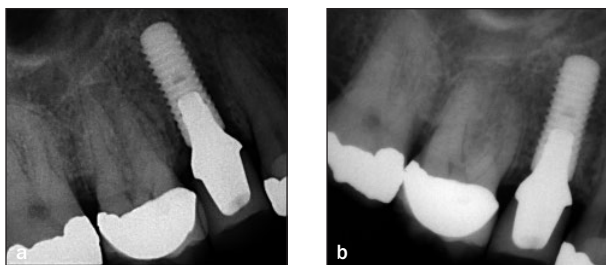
Radiographic images of representative case (same case as in Fig 1). (a) Preoperative and (b) 12-month postoperative presentation.
